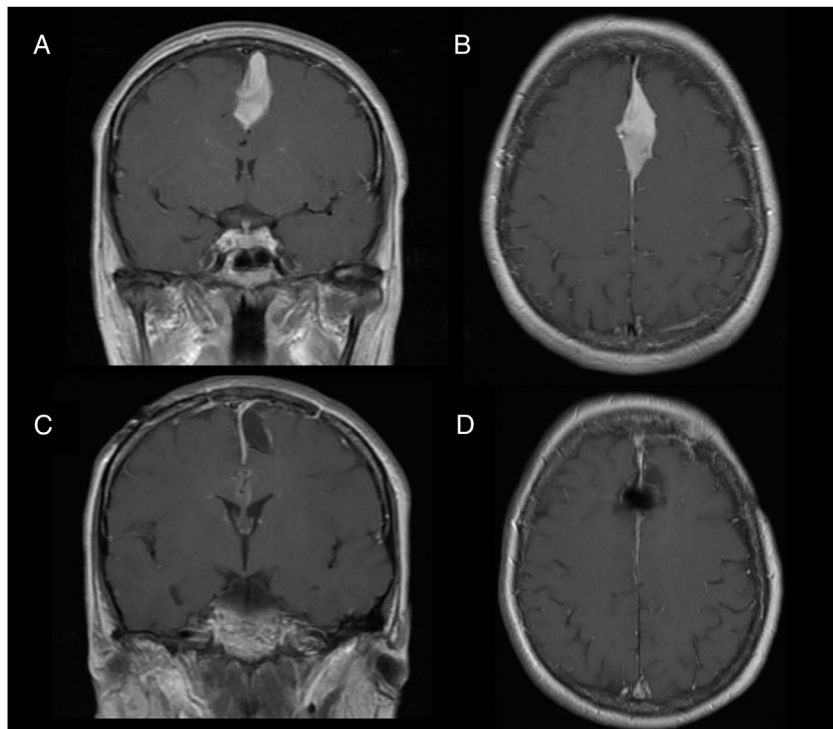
Patient 1: T1-weighted MRI scan with contrast administration. A and B) Preoperative images of recurrent tumour (patient recently admitted to hospital). C and D) Postoperative follow-up images.
